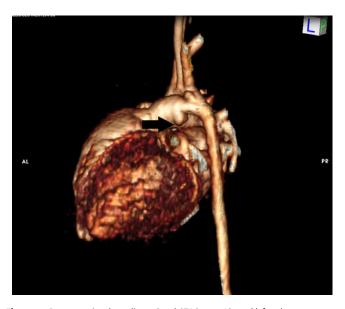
Preoperative three dimensional CTA image. Large PDA (white arrow).
